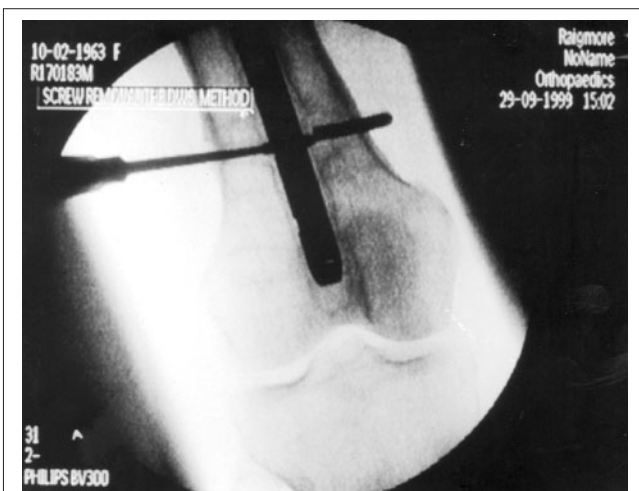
Intraoperative radiograph demonstrating use of bone awl.
